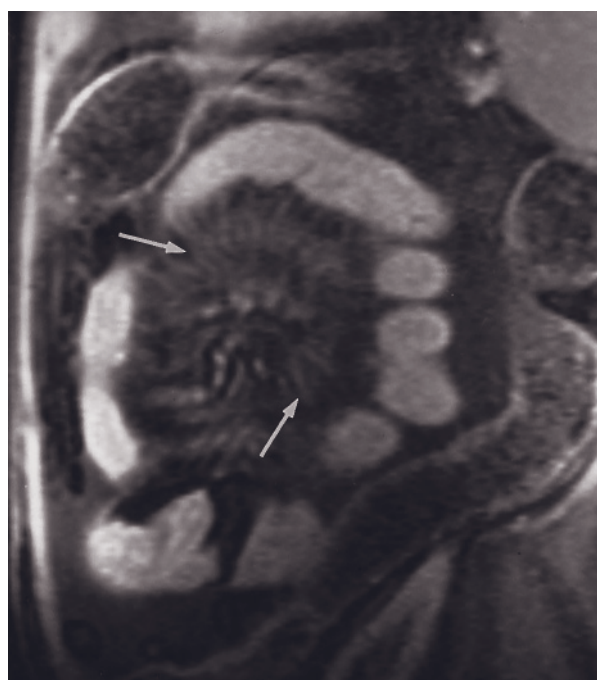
Mesenteric lipodystrophy. T1-weighted SGE image (a) demonstrates low-signal-intensity stranding in the fat of the mesentery (long arrows, a) consistent with mesenteric lipodystrophy. A small ventral hernia is also present (arrow, a). Coronal T1-weighted SGE (b) and T2-weighted single-shot echo-train spin-echo (c), axial T1-weighted SGE (d), and axial T1-weighted fat-suppressed interstitial-phase postgadolinium 3D-GE (e) images at 3.0 T in another patient show mesenteric panniculitis (arrows, b-e). There is stranding (arrows, b-e) along the mesentery that demonstrates low signal intensity both on T1-weighted SGE images and T2-weighted images and mild to moderate enhancement on postgadolinium image.
